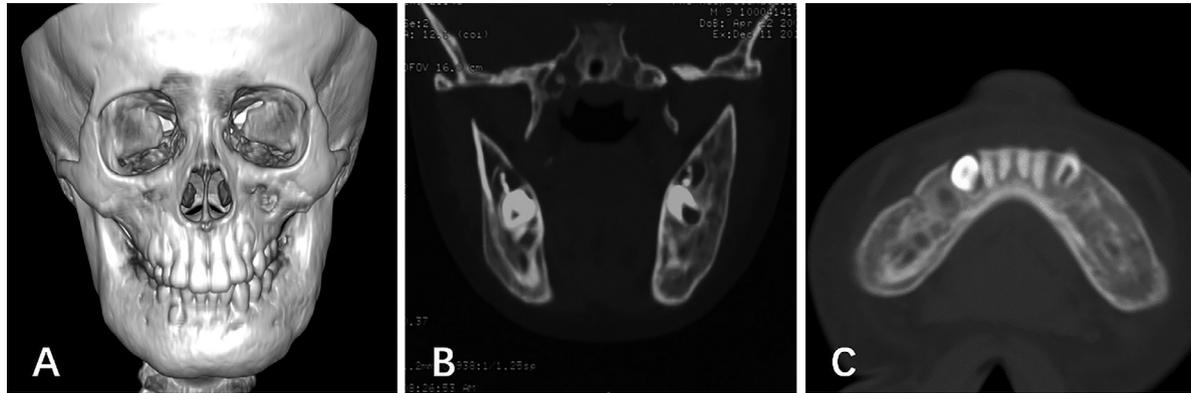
Computed tomography (CT) images at 3 months after treatment, showing evident bone cortex reconstruction, but sclerosis of the cancellous substance are still present.
